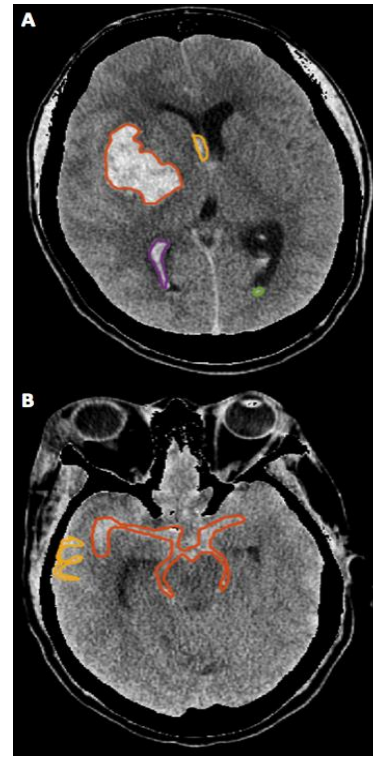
Examples of intracranial hemorrhages and annotations: (A) intraparenchymal (orange), intraventricular (yellow, purple, green). (B) subarachnoid (orange, yellow). CT attenuations of <0 or >100 HU are displayed as black (bones appear as black).
